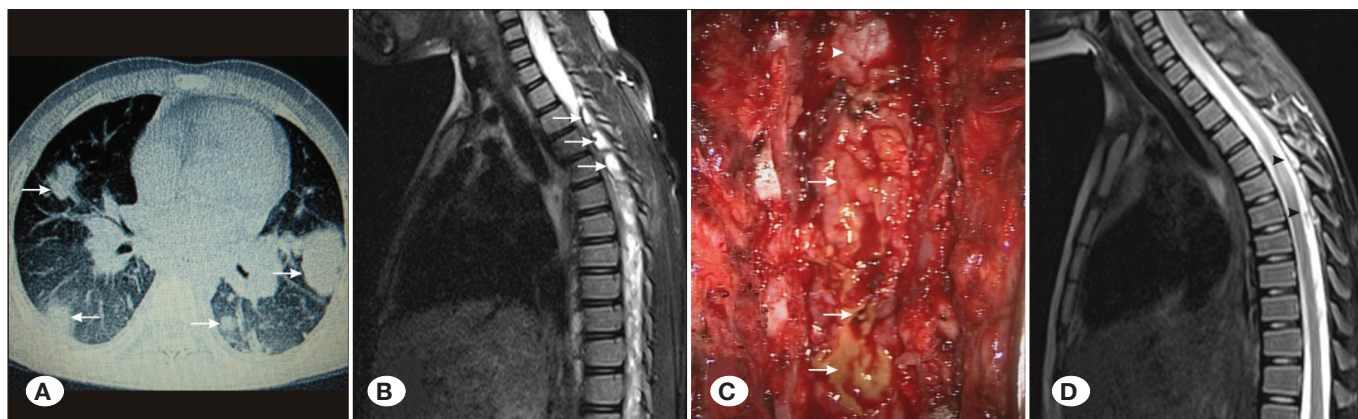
Spinal paragonimiasis. A) Lung lesions (arrows), B) T2-weighted MR image of a longitudinal extradural mass with multiple ring-shaped lesions (arrows), C) Spinal dura (arrowhead) and epidural lesion during the operation (arrows), D) T2-weighted MR image of the postoperative follow-up (arrows).
